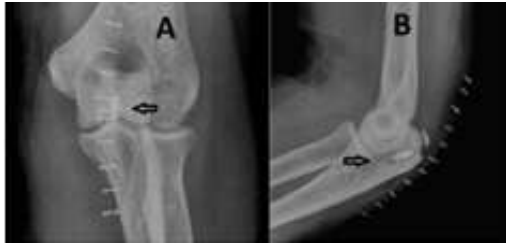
The post operative anteroposterior (A) and the lateral radiograph (B) of the elbow of the patient who underwent repair of the bony avulsion of the triceps. The triceps was repaired using the anchors (arrow head).
